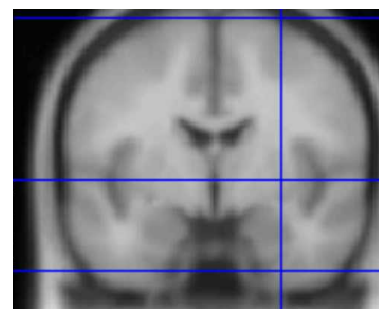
The current MNI template is the ICBM152. It comes from the average of 152 MRI scans matched to the MNI305, which is the first MNI template. This first template was obtained by averaging and matching 305 MRI scans to structures from the Talairach atlas. Source: <http://imaging.mrc-cbu.cam.ac.uk/imaging/MniTalairach>
